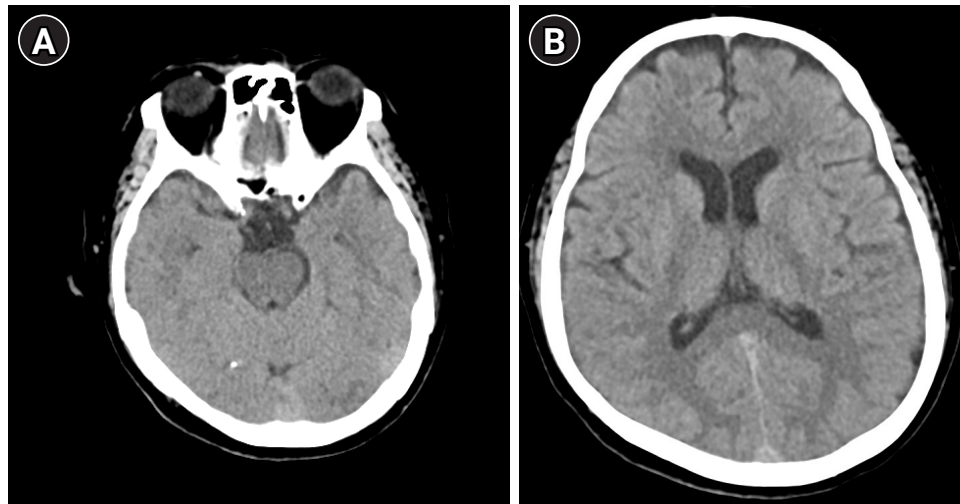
Follow-up brain computed tomography (CT) obtained 5 days after the initial study. (A) Axial CT at the level of the basal cistern showing complete resolution of the previously noted pneumocephalus. (B) Axial CT at the level of the lateral ventricles showing resolution of the intraventricular air at the corresponding level.
